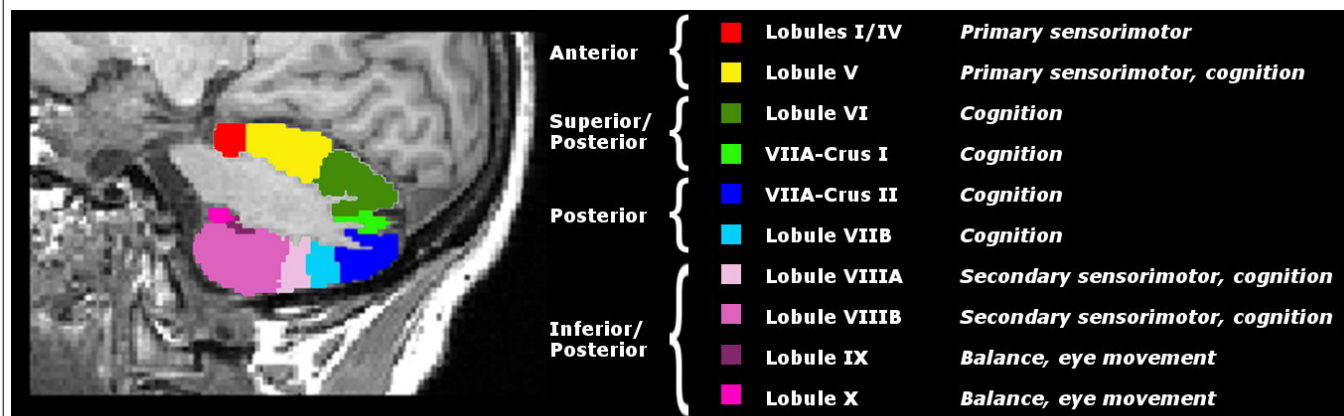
Segmentation of the cerebellar lobules (left side) mapped on a 3T T1-weighted MR image of a control subject. Classification was made according to Bogovic *et al.*, NeuroImage 2013;64:616–629 and Pierson *et al.*, NeuroImage 2002;17:61–76. Cerebellar functions were based on Makris *et al.*, Journal of Cognitive Neuroscience 2003;15(4):584–599.
